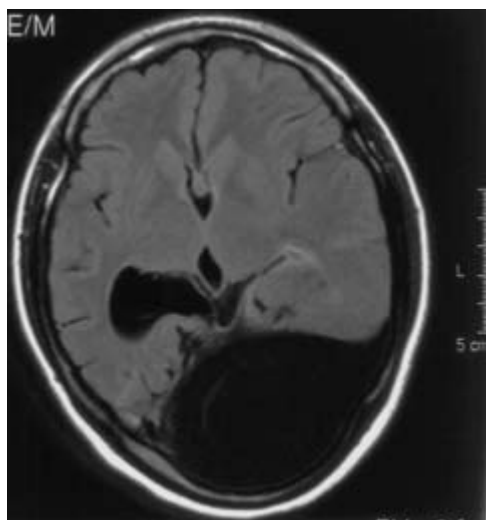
Patient no. 8. Axial FLAIR image. Big cyst in the left cerebral hemisphere.
